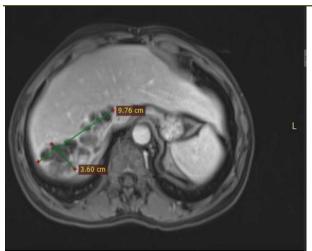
Shows measurement of baseline MRI in segment VII of liver
